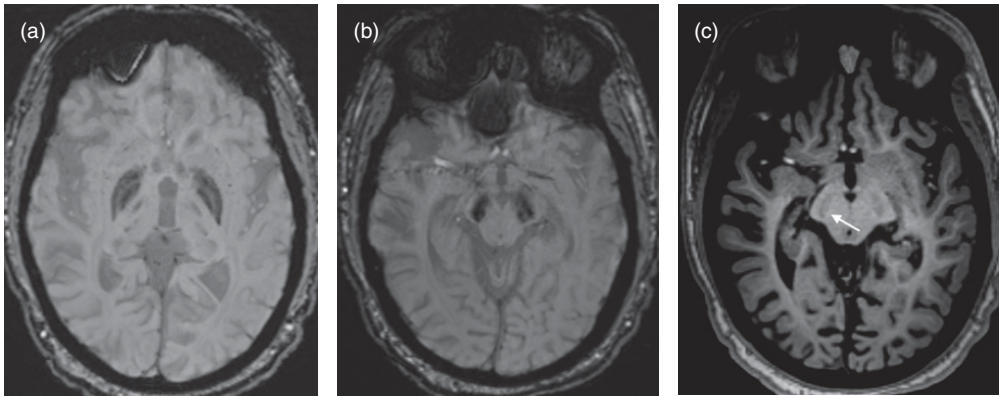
Adult with developmental delay, intellectual disability, and spastic quadriparesis with regression as a teenager. Ultimately found to have a *WDR45* mutation on exome sequencing. Axial SWI demonstrates abnormal iron deposition in (a) the globus pallidus and (b) the substantia nigra. (c) On axial T1-weighted imaging, there is subtle T1 hyperintensity surrounding the substantia nigra (arrow), which is a unique feature of BPAN.
